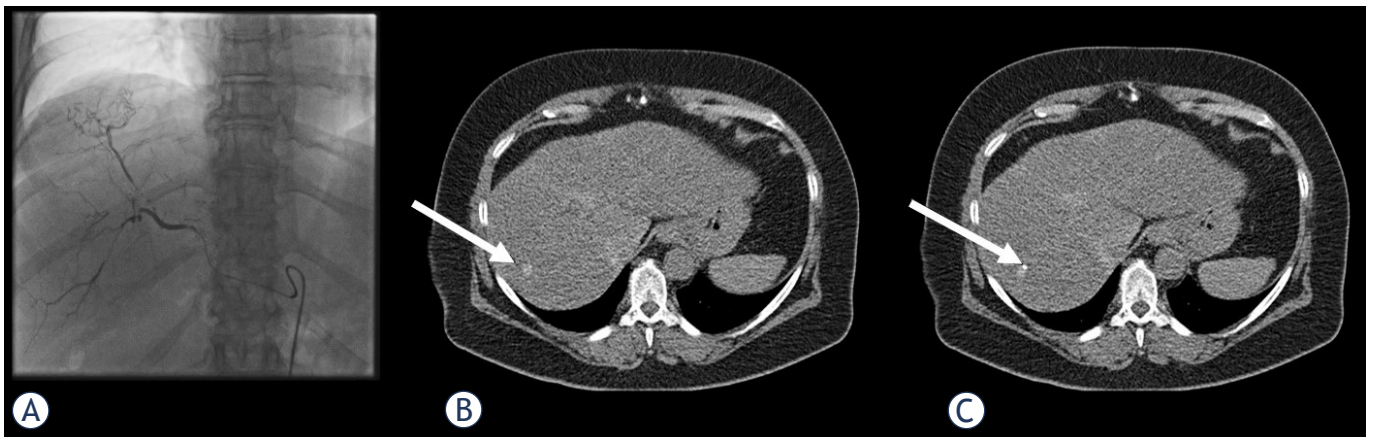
The decision for a biopsy of the suspicious hepatic lesion was made for the same male patient. Because of the small lesion size and isodensity in the unenhanced CT, a prior intra-arterial Lipiodol-marking (A) was performed. Directly after the intervention (B) and during the CT intervention (C) (white arrow) was well displayable, and the biopsy was successful, revealing a hepatocellular carcinoma.
